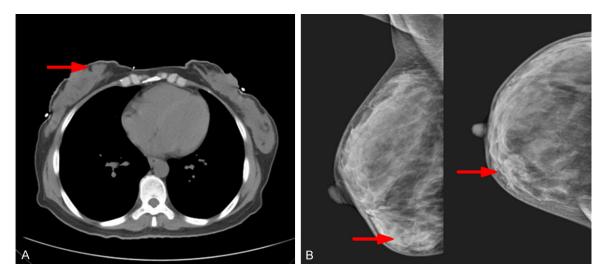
Chest CT scan (A) and breast mammography (B) showed masses (arrow) in the patient's lower inner quadrant of her right breast, and the size of the bigger one was 18×25 mm.
